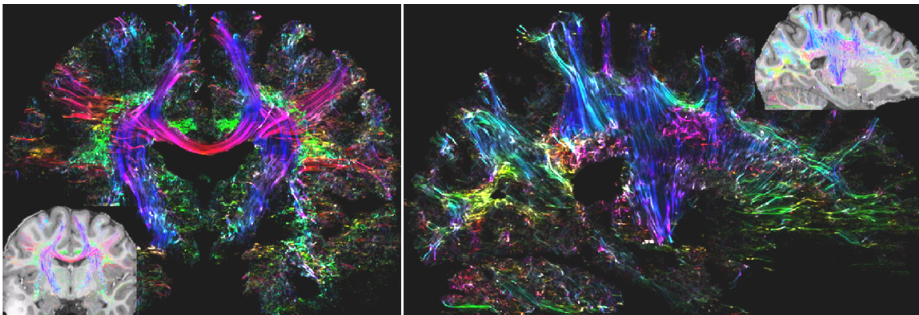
Tract-density imaging maps derived from the 1mm isotropic resolution rs-EPI acquisition showing the coverage of the DWI. The small images in the corner show the TDI maps overlaid onto the anatomy.
